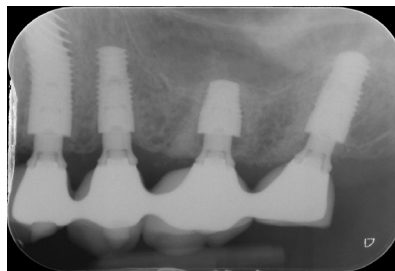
Radiograph at 5 years follow up.*
